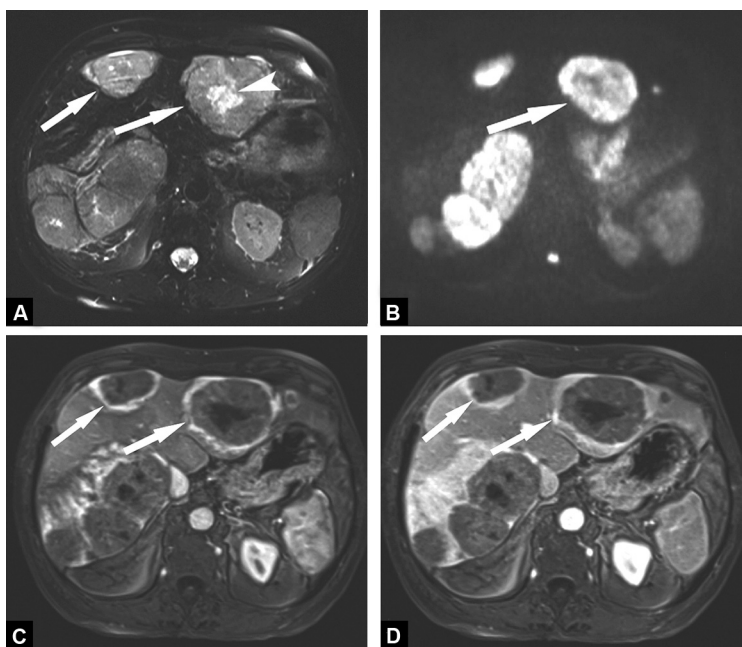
Magnetic resonance (MR) imaging examination of the liver in the transverse plane. A. T2-weighted fat suppressed fast spin echo MR image (TR/TE = 2913/91 ms) shows multiple, heterogeneous, hyperintense liver lesions (arrows) with a more intense central portion (arrowhead) for some of them. B. Diffusion-weighted MR image (echo planar imaging, TR/TE = 6100/105 ms, $b = 800 \text{ s/mm}^2$) shows multiple hyperintense liver lesions, indicating restricted diffusion. Some of them have a more marked hyperintense center displaying the target sign (arrow). C. Three-dimensional T1-weighted VIBE MR image (TR/TE/ $\alpha = 4.17/1.67 \text{ ms}/15^\circ$) obtained during the arterial phase following intravenous administration of a gadolinium chelate (Gadoterate meglumine, Dotarem[®]; Guerbet, Roissy-Charles de Gaulle, France) shows multiple liver lesions with a peripheral rim of enhancement (arrows). D. Three-dimensional T1-weighted VIBE MR image (TR/TE/ $\alpha = 4.17/1.67 \text{ ms}/15^\circ$) obtained during the portal phase of enhancement shows persisting peripheral rim of enhancement (arrows).
